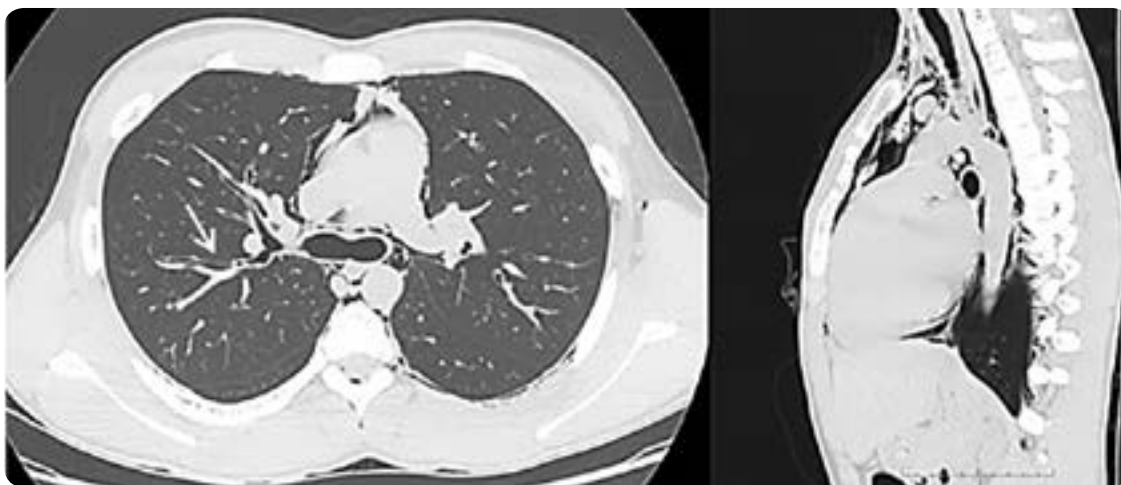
16-year-old patient with severe asthmatic crisis. Axial and sagittal cut of chest CT: air is identified that dissects the perivascular and peribronchial spaces (Macklin effect), which extends towards the mediastinum and affects the acygoesophageal space, descending aorta, acygos vein, pre-vertebral and paravertebral space, as well as the medullary canal
